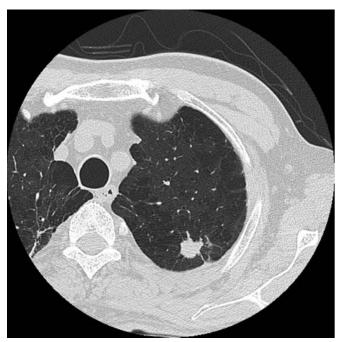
Radiographic findings of the tumor: Computed tomography of the chest reveals a well-defined and lobulated solid nodule measuring 2.4cm in diameter in the left peripheral S^{1+2b} segment.
